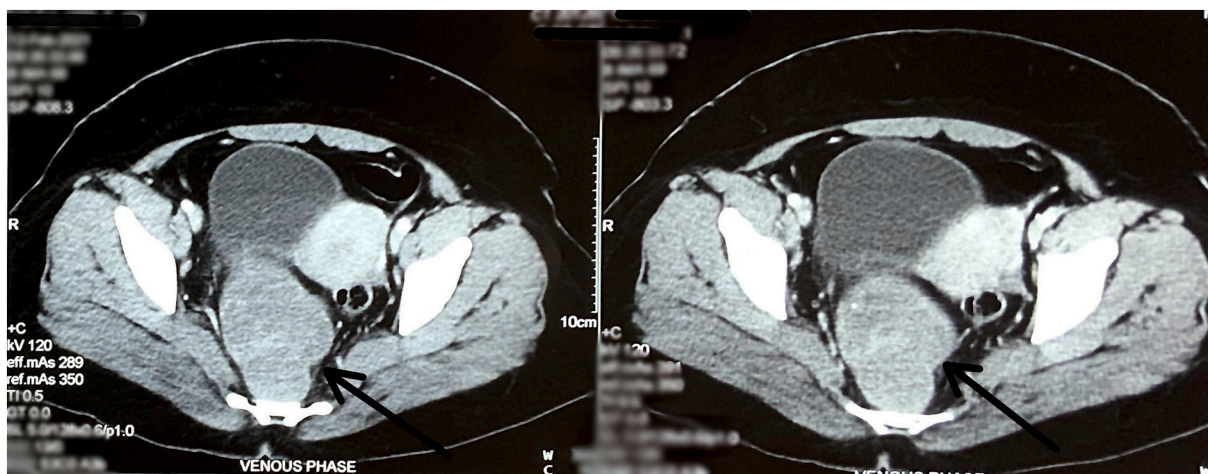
Contrast-enhanced CT scan of the pelvis shows well-defined heterogeneously enhancing oval lobulated soft tissue density in the presacral region (arrows).
